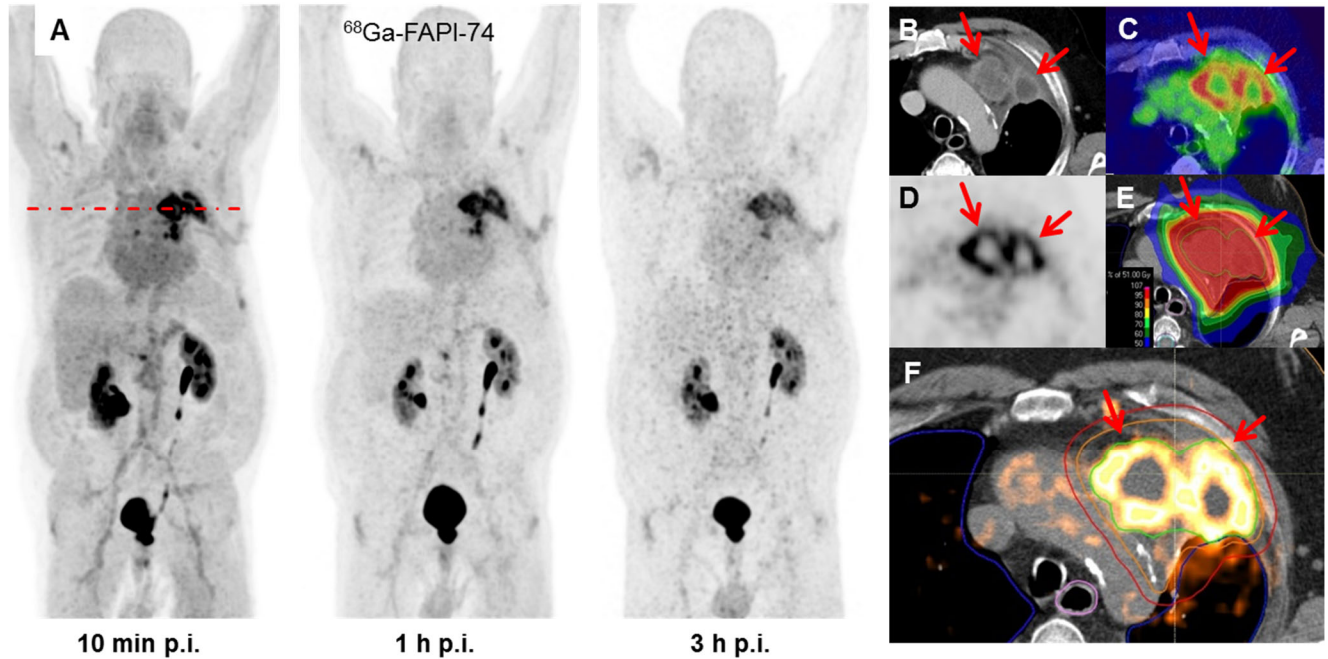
Maximum-intensity-projections of ^{68}Ga -FAPI-74 PET at 10 min, 1 h and 3 h p.i. (A). Direct comparison of contrast enhanced CT (B), FAPI-PET (D) and Fusion (C). Superior tumor delineation consecutively improved dose application to tumor volume using a volumetric-modulated arc therapy (VMAT); green line: gross-tumor volume (GTV); orange line: clinical target volume (CTV); red line: planning target volume (PTV) (E, F).
